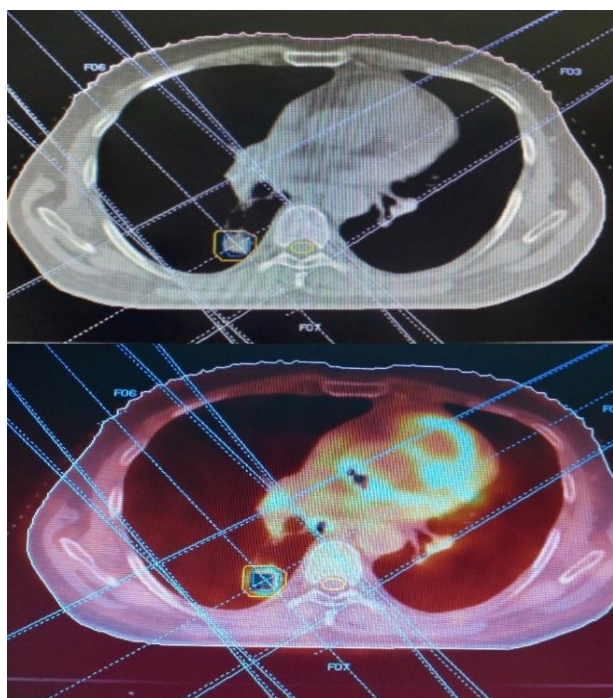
Comparison of GTV contoured using CT data only (a) and using the fused PET data (b) for one of the patients in the present study. (Orange border contoured with PET and blue border contoured with CT)
